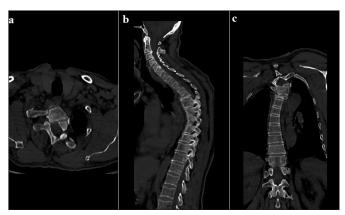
Preoperative CT images
